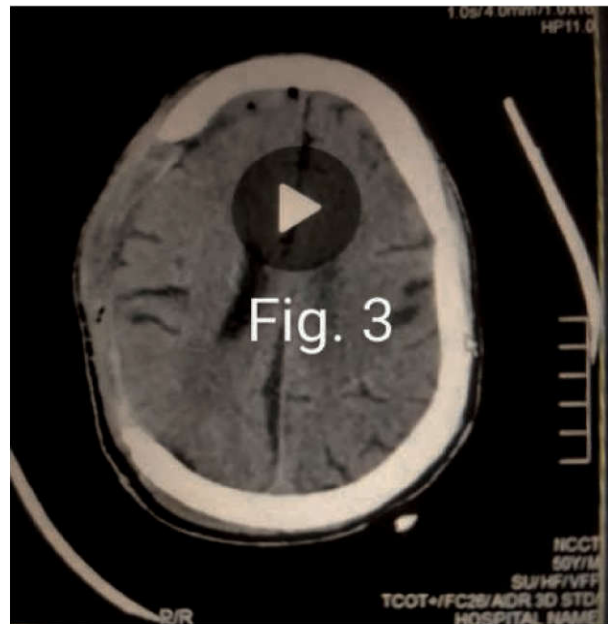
Initial CT scan of brain.
